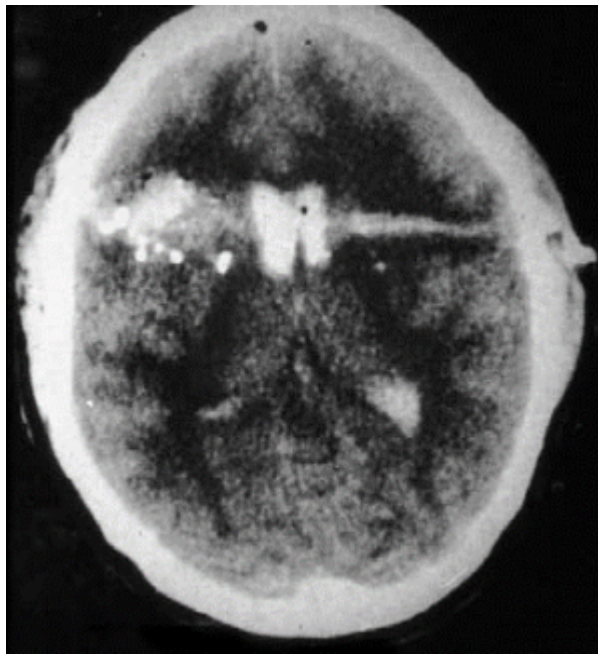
CT appearance of gunshot trajectory in the brain tissue
